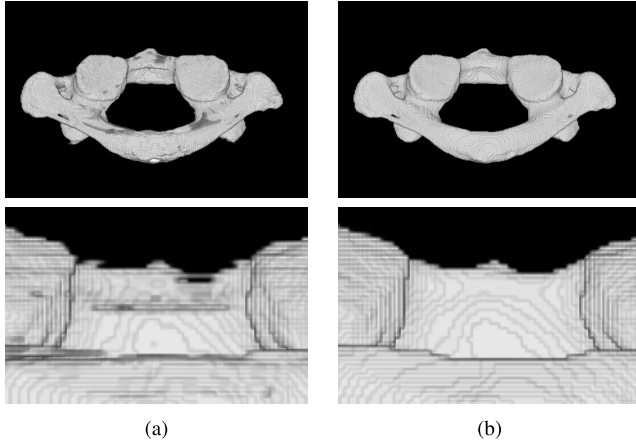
3D segmentation and interpolation of the c1 vertebrae of Figs. 3a and 3b from a CT-scan. (a) our previous method [8], (b) proposed method. Top row: global view, bottom row: zoomed view.
